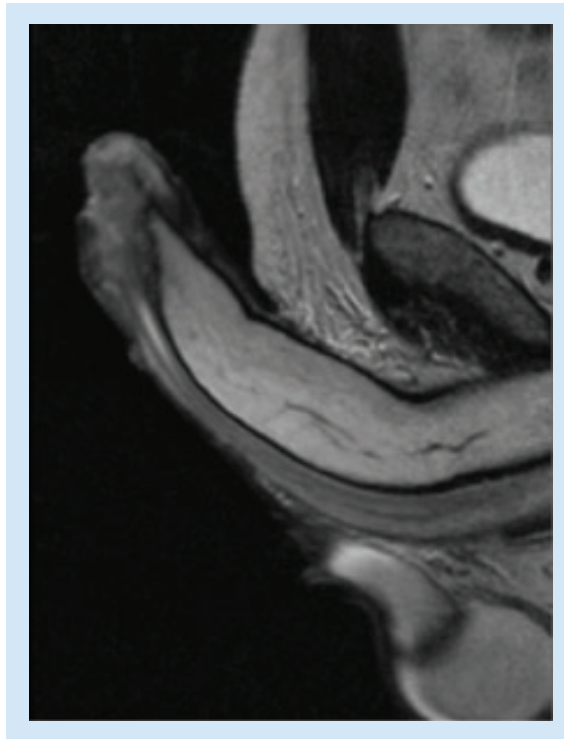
MRI with caverject of a penile carcinoma.
